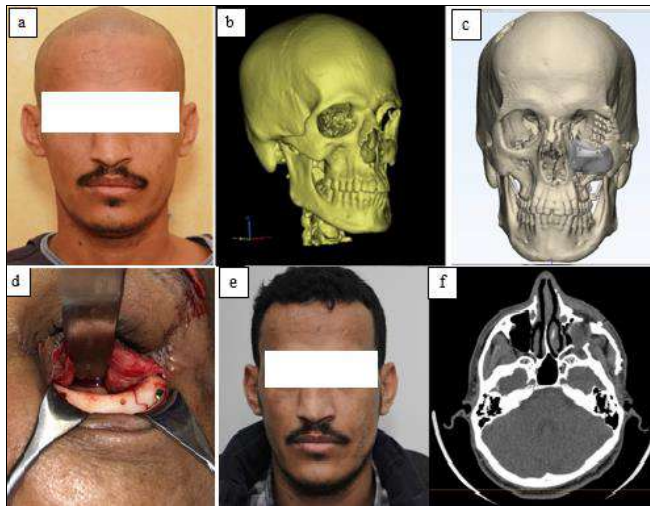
(a) Frontal view showing left sided infraorbital depression. (b) preoperative 3D reconstructed image showing the depression in left infraorbital region. (c) Preoperative 3D planning for the used implant with its relations to the adjacent structure in frontal view. (d) Intraoperative photos of the PSI through subciliary incision. (e) frontal view showing near identical infraorbital margins. (f) axial CT cut showing the PSI in place.
